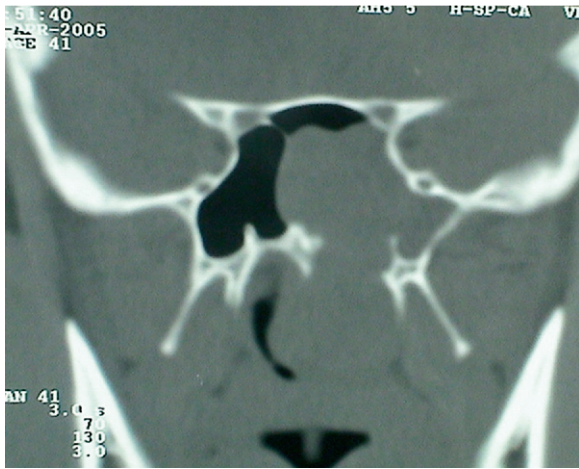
CT scan in the coronal view showing opacification of part of the nasal cavity and the sphenoid sinus.
